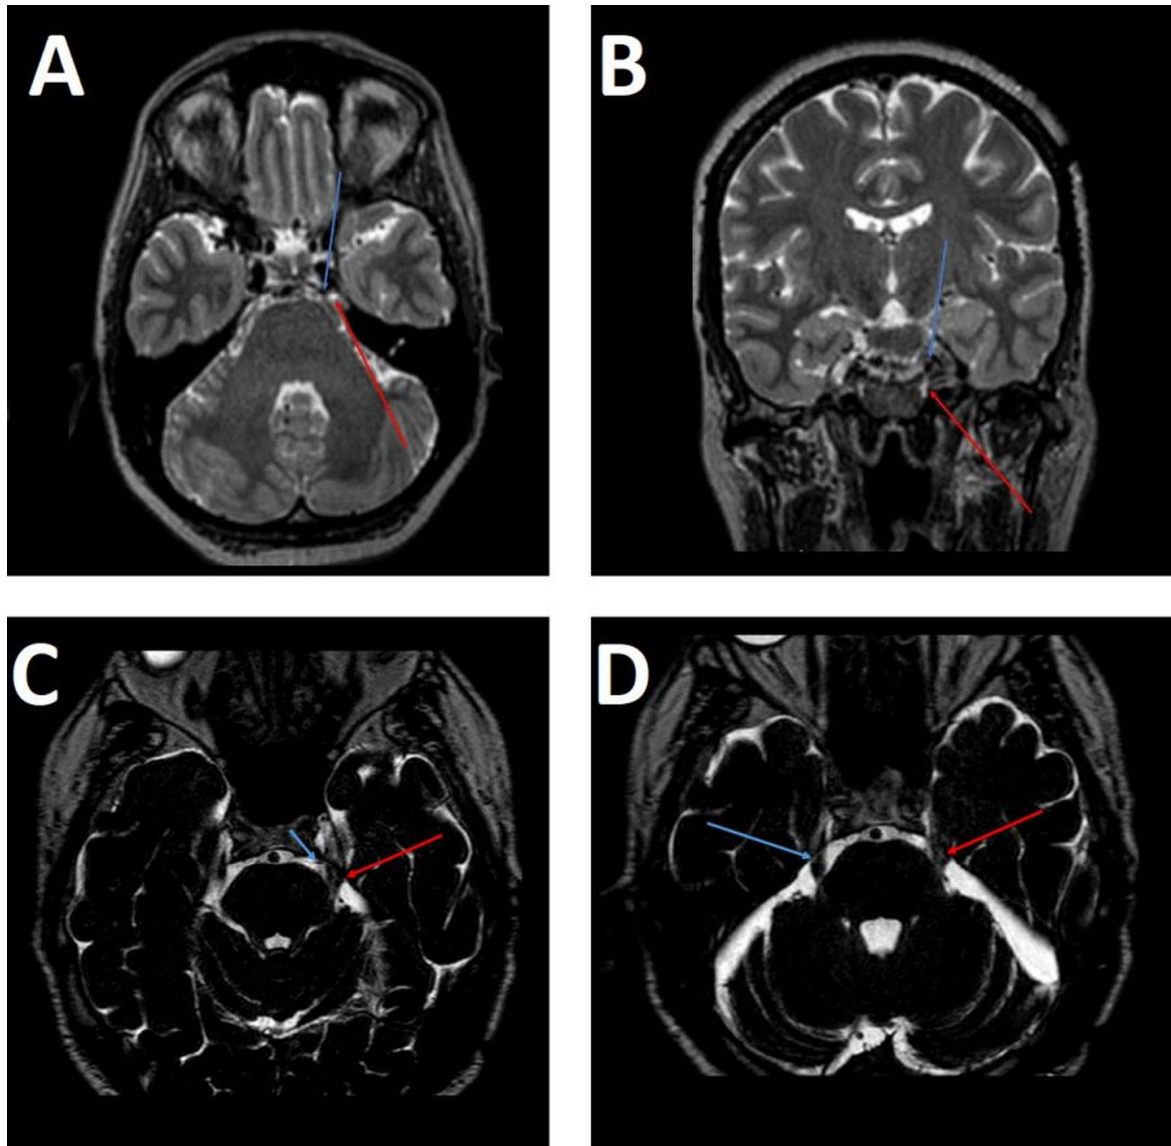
High-resolution T2-weighted magnetic resonance imaging (MRI). (A) Axial and (B) coronal volumetric sequences demonstrate neurovascular conflict between the left superior cerebellar artery (blue arrow) and the left trigeminal nerve (red arrow), with subtle signal alteration at the root entry zone, consistent with neuropathy. (C) Axial T2 3D sequence shows the left anterior inferior cerebellar artery (blue arrow) crossing the ipsilateral trigeminal nerve (red arrow), which appears diffusely thickened and with altered signal. (D) Axial T2 3D sequence demonstrates thickening and signal alteration of the left trigeminal nerve (red arrow) compared with the contralateral side (blue arrow), corresponding to Sindou grade II (morphological change without severe displacement). Note: Time-of-Flight (TOF) angiography and post-contrast T1-weighted sequences were not acquired in this case.
